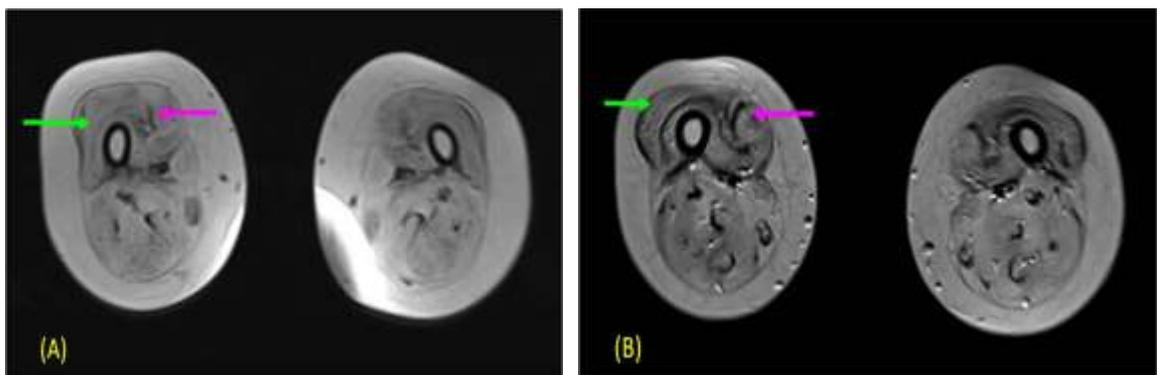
Figures, A & B show MRI Musculoskeletal images before and after stem cell therapy. Regeneration of muscles is seen in Fig B.
